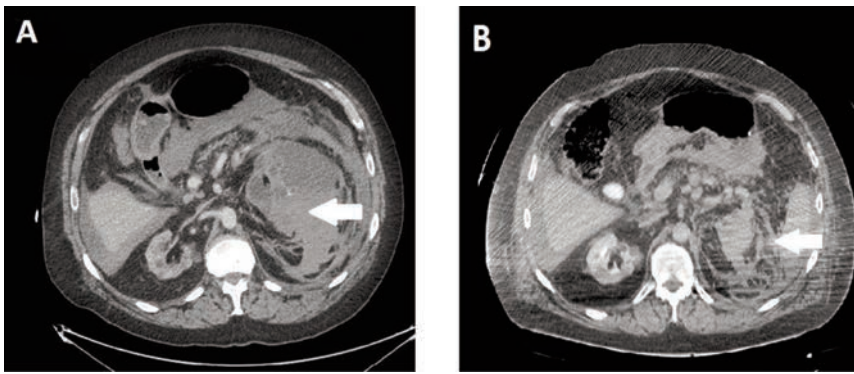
Unenhanced (A), corticomedullary phase CT scans showing a great amount of blood in the peri and para-renal left kidney zone, generated by a lesion of the kidney's parenchyma (B).
